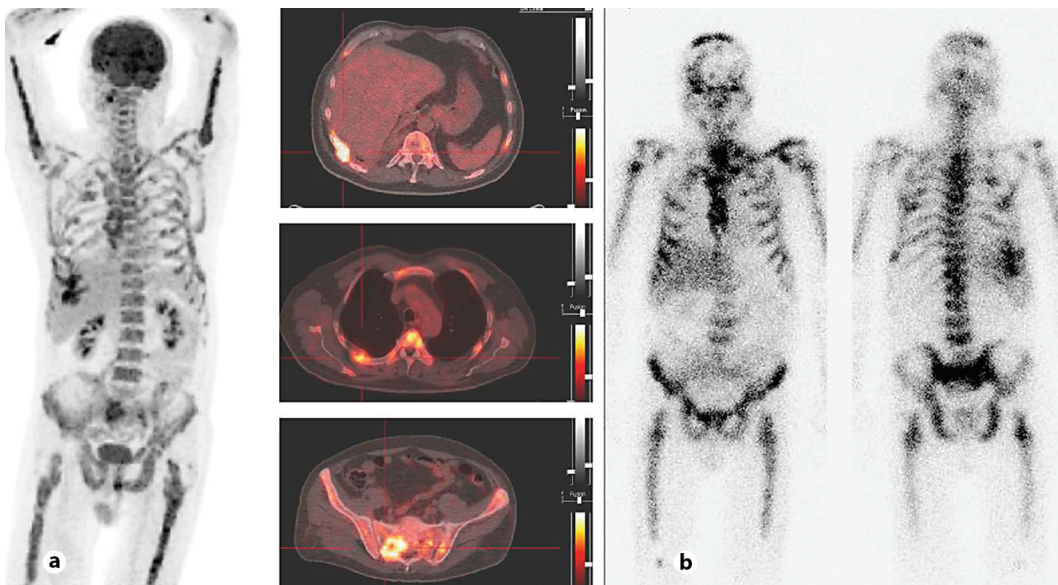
a Diffuse pathological glucose uptake in the bone marrow of the hollow bones and the vertebral bodies in the PET and PET-CT scan. b Diffuse iodine-131-MIBG uptake in the bone marrow, including the calvarium, as determined by MIBG scintigraphy.
